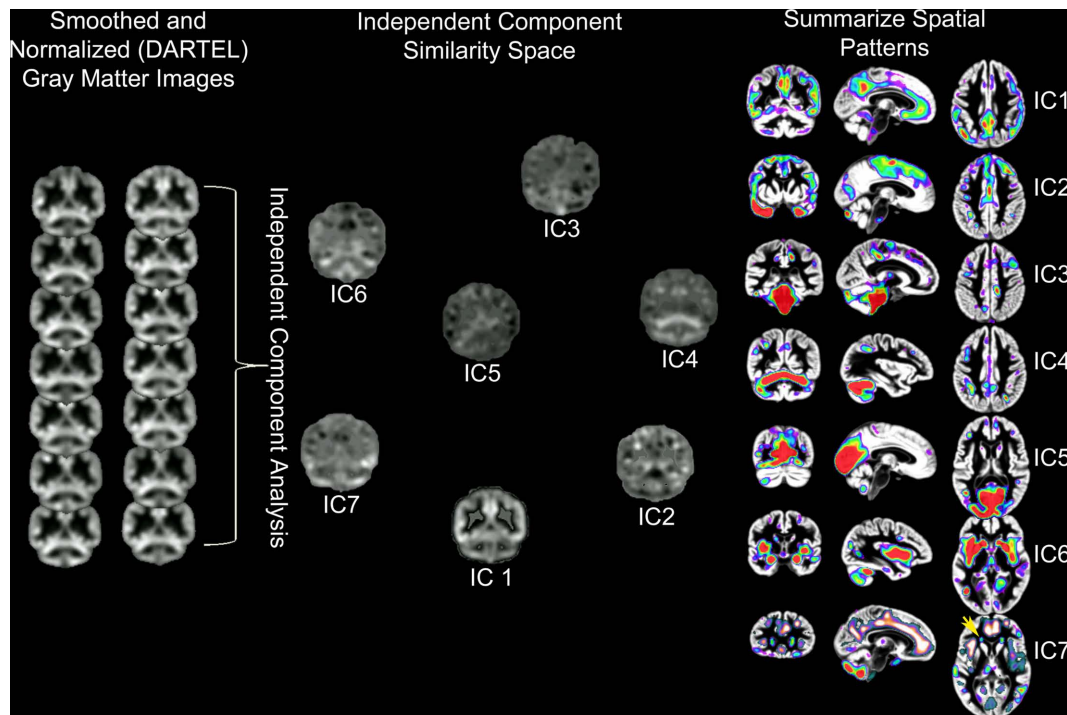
Source based morphometry or ICA of gray matter probability images across 42 subjects. Each subject's T1-weighted image is segmented to generate a gray matter probability image that is normalized to a common coordinate space and smoothed. ICA is performed across the sample of gray matter images. The degree to which each independent component (IC) or unique pattern of variance can be compared to the other ICs with a variety of metrics, including an estimate of similarity space. The brain regions that contribute most to each component can be identified by displaying each component with scaled intensity values (Z score = 1–3 above). Each IC also has an inverse component
